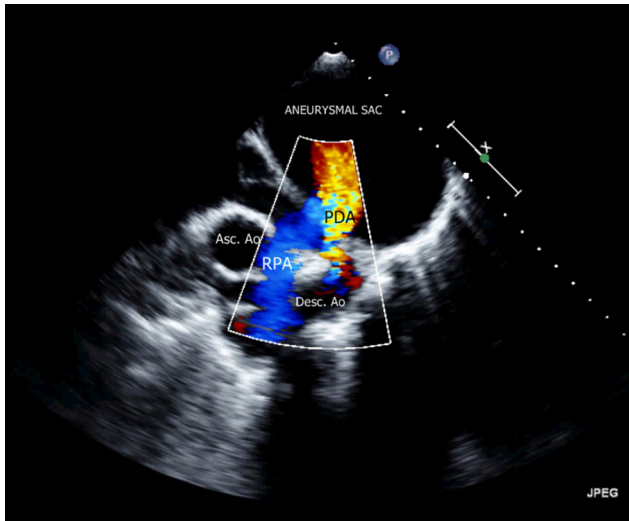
Parasternal short axis view in 2D echocardiography with color Doppler showing huge aneurysm of LPA (left pulmonary artery) supplied by PDA. Asc. Ao – Ascending Aorta, Desc. Ao – Descending Aorta, PDA – Patent Ductus Arteriosus, RPA – Right Pulmonary Artery.
